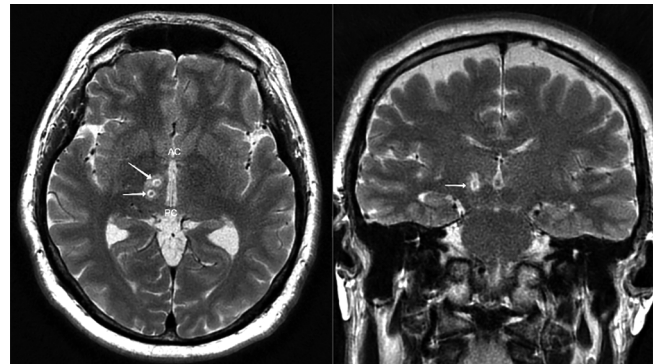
Patient's MRI scan 2 h after simultaneous right-sided PTT + VIM ablation (axial and coronary planes). Ablation lesions are shown with arrows.
